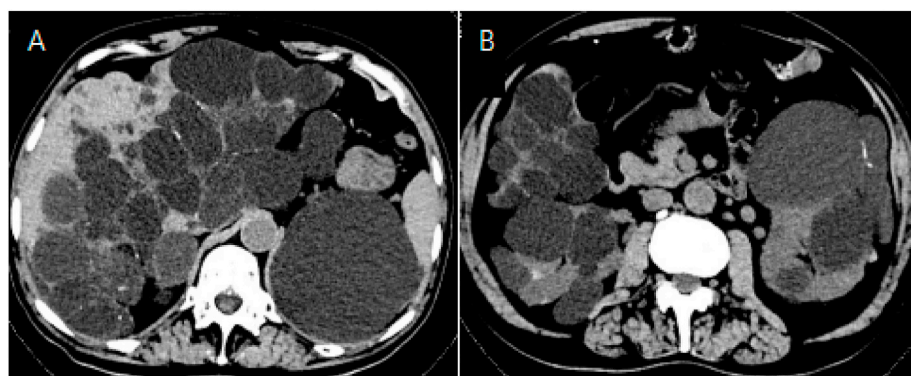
Preoperative computed tomography scan of the transplant recipient's abdomen. (A) The liver is enlarged, with a rough surface, moderate dilation of intrahepatic bile ducts, and widened hepatic fissures. Multiple round hypodense shadows are visible, with calcifications noted in some of the cystic walls. (B) Multiple round hypodense shadows are visible in both kidneys.
